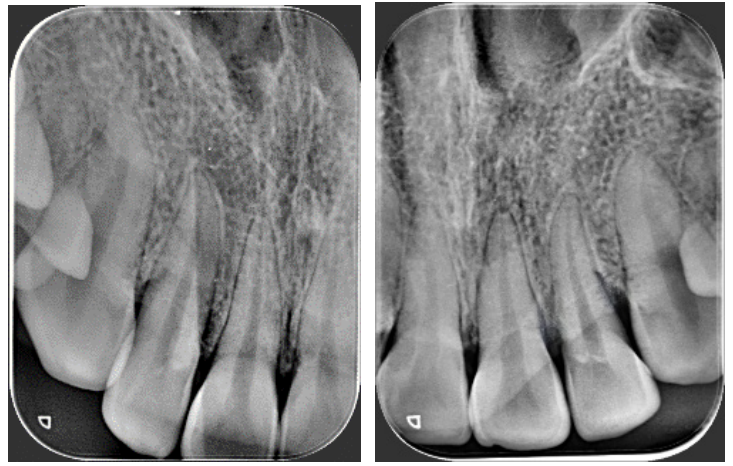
Post-operative one year follow up radiograph
